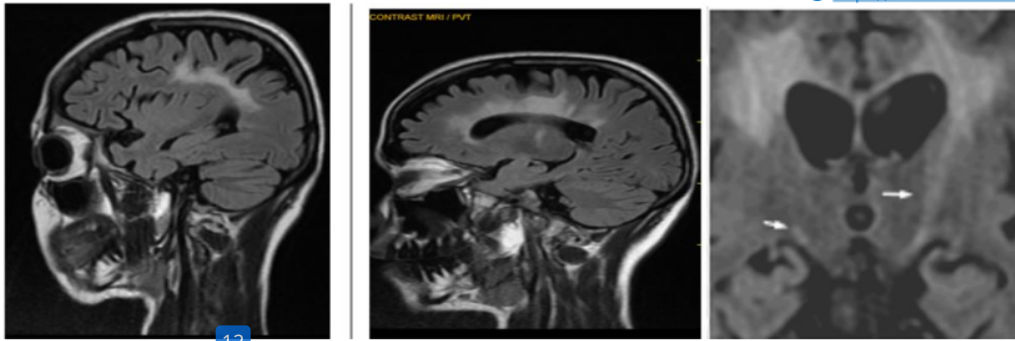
Confluent symmetrical T2/FLAIR hyperintensities involving the periventricular white matter of bilateral cerebral hemispheres and bilateral pyramidal tracts. Diffuse cerebral and corpus callosal atrophy.
